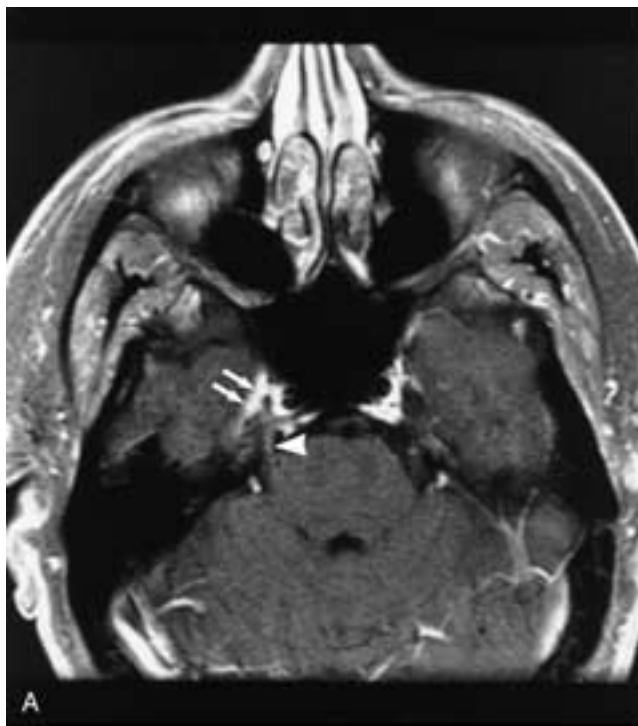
Squamous cell carcinoma of the right forehead with very subtle PNS along the ophthalmic nerve (V_1). One year after excision of the primary skin cancer, the patient developed sensory neuropathy in the entire right trigeminal distribution. Axial (A) and coronal (B) contrast-enhanced, fat-suppressed T1-weighted MR images show very subtle abnormal enhancement within Meckel's cave on the right (*arrows* in A and B) and even subtler enhancement of the main trigeminal trunk (*arrowhead* in A). Biopsy of the right supraorbital region confirmed perineural infiltration of the supraorbital branch of V_1 . The abnormal enhancement was presumed to represent a skip lesion originating on V_1 , as there was no imaging evidence of tumor in the orbit, superior orbital fissure, or cavernous sinus. The patient received radiotherapy, as the disease was deemed inoperable. C, Axial contrast-enhanced, fat-suppressed T1-weighted MR image obtained 8 months after A and B shows massive disease recurrence/progression with bulky tumor in Meckel's cave (*asterisk*) and the pons (*black dot*).
